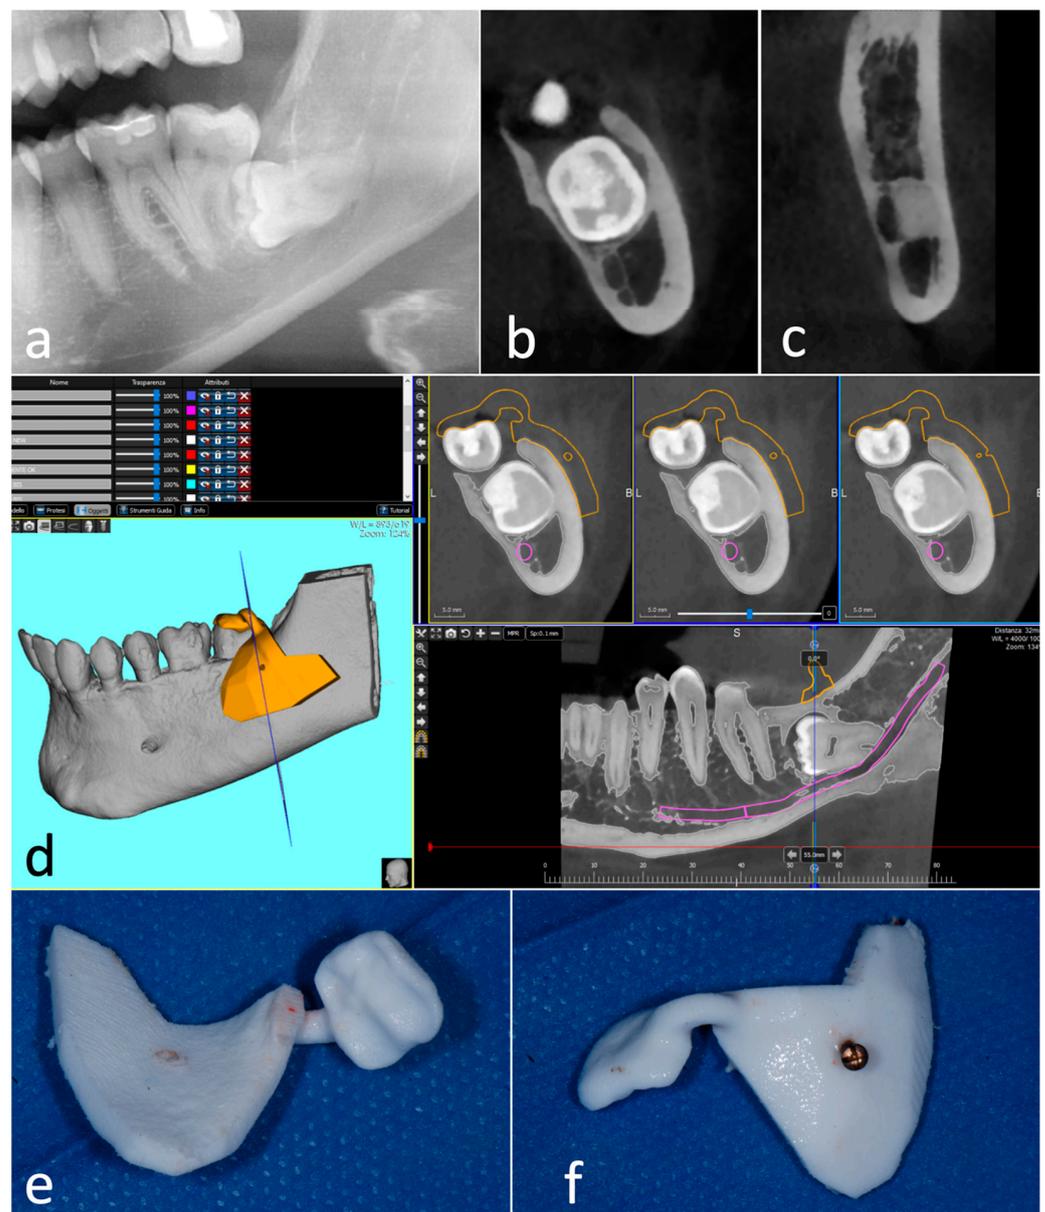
Case 2. Impacted tooth 38 with periodontal probing distal to 37. (a) Preoperative orthopantomography; (b,c) details of the CT scan demonstrating the consistent thickness of the buccal wall and the proximity to the mandibular canal; (d) surgical guide planning; (e,f) surgical guide with the fixation screw inserted.
